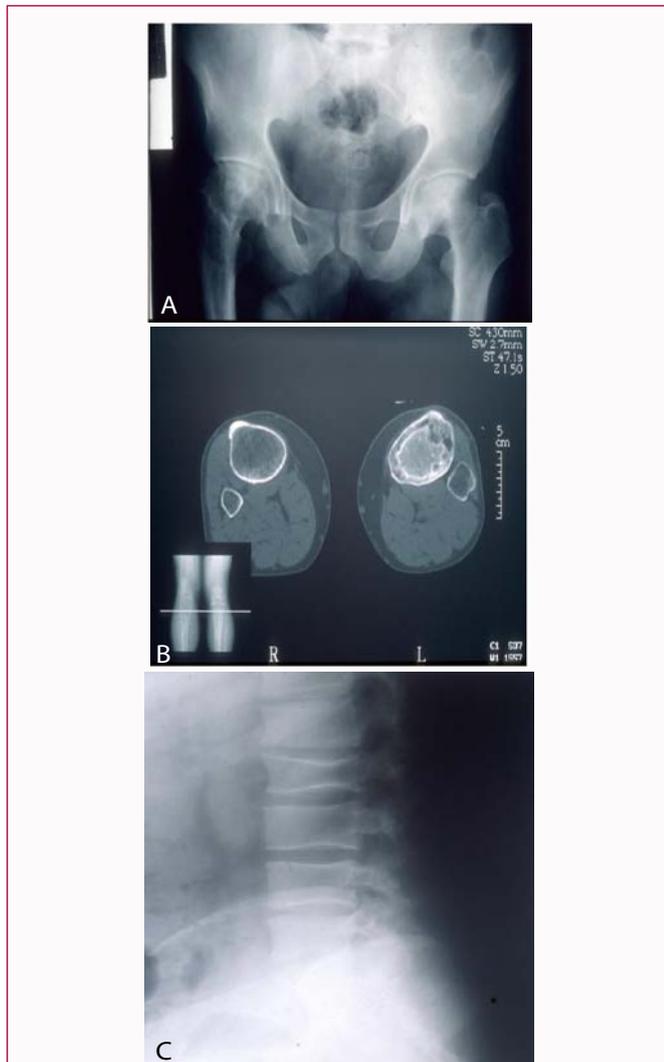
Case 5: (A) Frontal pelvic radiograph showing bilateral AVN of hip joints, (B) Computed tomography image showing bone infarcts in the left tibia, (C) collapsed L2 vertebra shown in lateral cervical spine radiograph.
